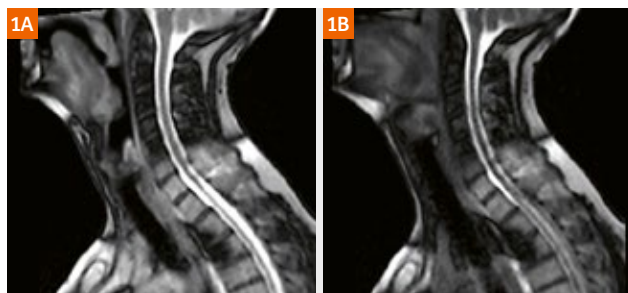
Sagittal TrueFISP MRI sequences for assessment of laryngeal motion showing most inferior (1A) and most superior (1B) larynx position during swallowing.
